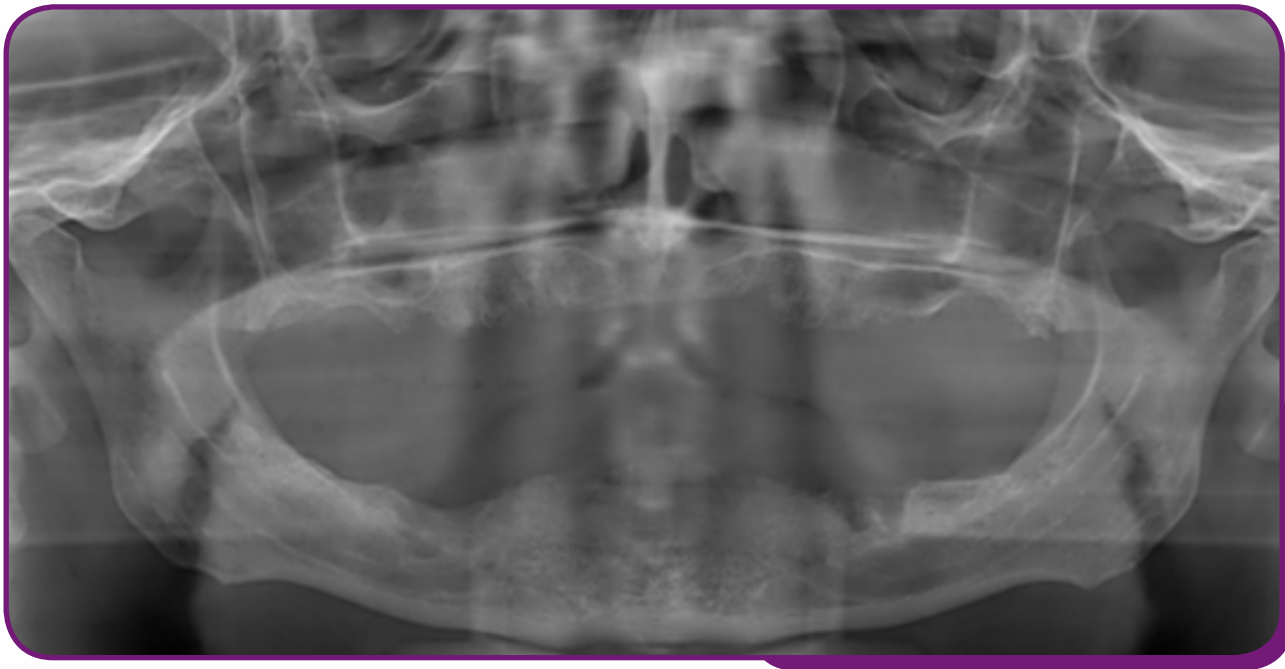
Panoramic radiography of an edentulous patient
